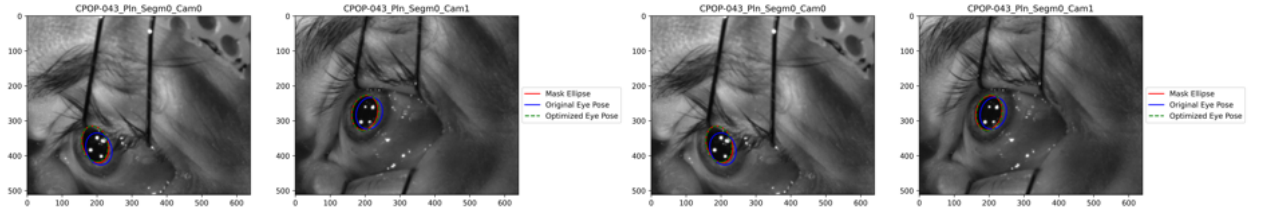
Patient CPOP-043 eye pose optimization for the original MRI model and the optimized corneal curvature model respectively. Both optimizations yielded better results in the separate strategy where pose and pupil size are handled aside.
